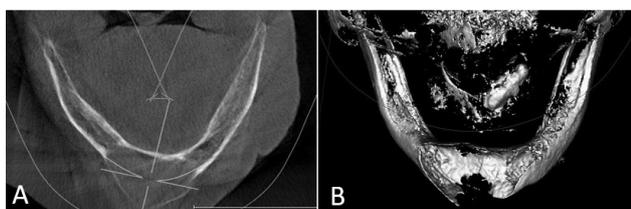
(A) Axial view of the lesion on the CBCT; (B) View of the lesion on 3D reconstruction
